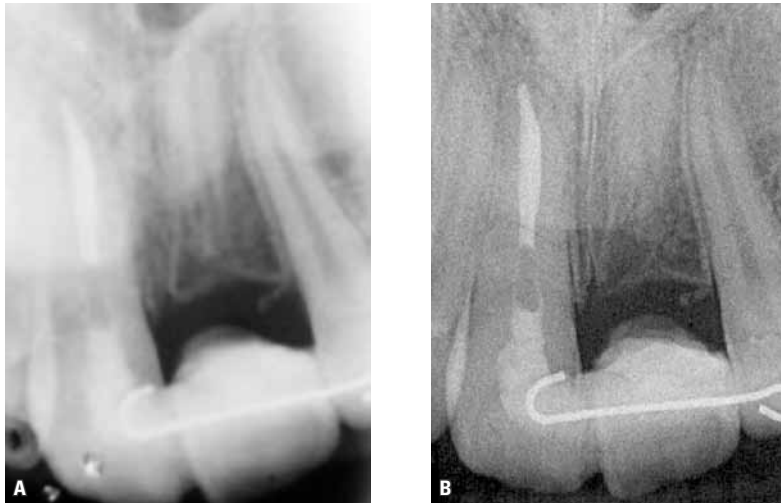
A) Periapical radiograph immediately after crown amputation and burial of the root of tooth 21. B) Periapical radiograph 8 months after crown amputation.
